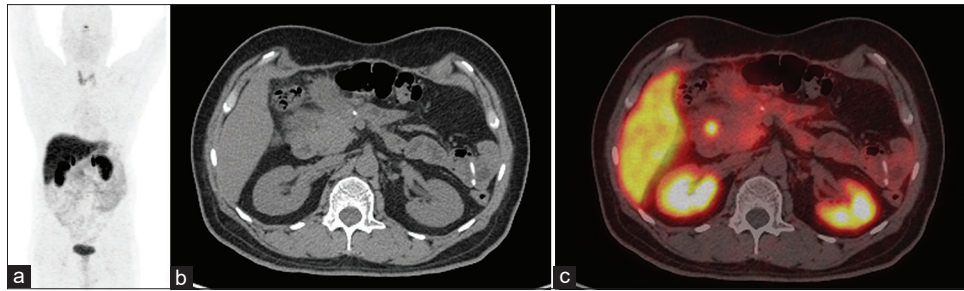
Case of 49-year-old male who was a follow-up case of Neuro-endocrine tumor (Grade 2) of the Pancreas (tail), post resection and hepatic metastectomy. The patient was sent for 68Ga-DOTANOC Positron emission tomography/computed tomography in view of rising Serum Chromogranin levels (MIP [a], Axial computed tomography [b], Axial positron emission tomography/computed tomography [c]); which revealed a Somatostatin Receptor expressing lesion in the second part of the duodenum and no other site of involvement. The 68Ga-DOTANOC Positron emission tomography/computed tomography was able to identify such low-burden recurrence at an early stage and patient was offered radical treatment
